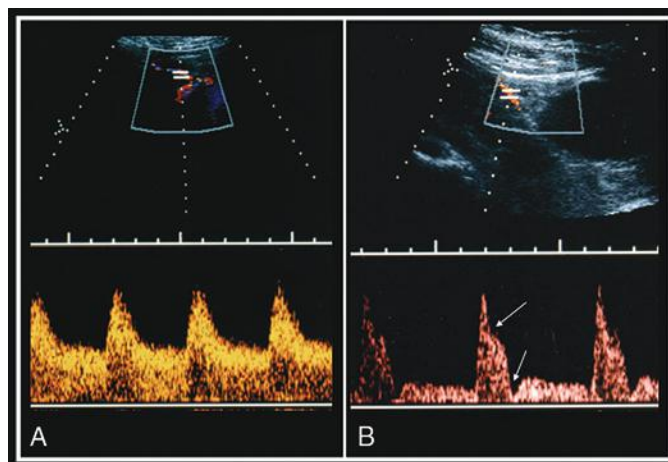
Doppler waveforms of the uterine artery obtained in the late second trimester of pregnancy showing normal uterine circulation (A) with increased end-diastolic velocity implying low-impedance circulation and abnormal uterine artery circulation (B) with a waveform notch (top arrow) and low end-diastolic velocity (high impedance) (lower arrow).
